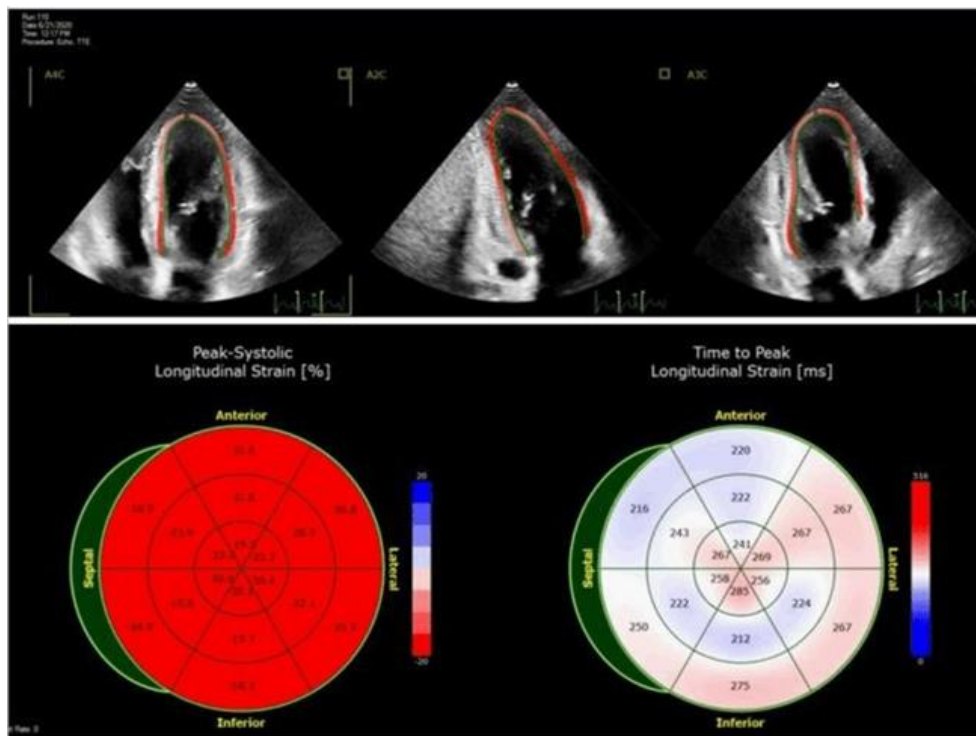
Global longitudinal strain by speckle tracking echocardiography (14) .
